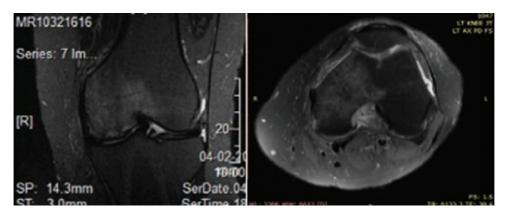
Posttreatment MRI T2W coronal and axial sections of the knee joint showing considerable resorption of the bone edema after 16 weeks of the combination therapy.
